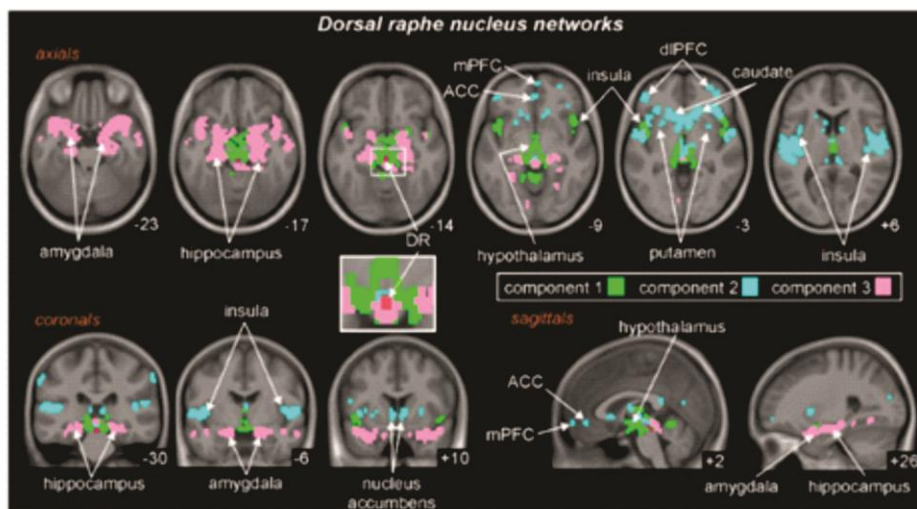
Three separate signal intensity change pattern maps (Components 1, 2, and 3), each including the dorsal raphe nucleus (DR) overlaid onto a mean T1-weighted anatomical image set. Note that signal intensity within the DR covaried with the signal intensities within the amygdala, hippocampus, hypothalamus, anterior cingulate cortex (ACC), medial
